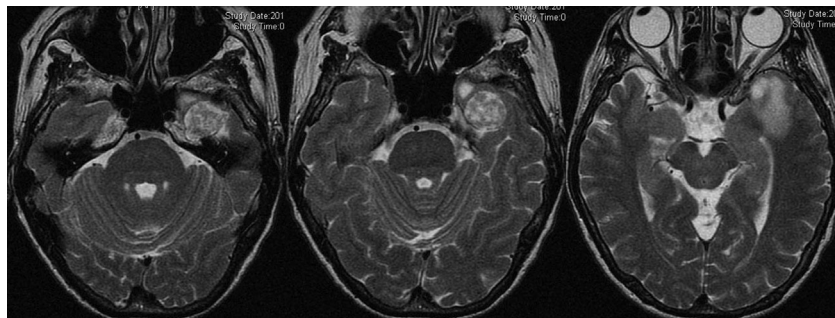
Axial T2-weighted magnetic resonance imaging shows a tumor located at the middle fossa with associated hyperintensity consistent with temporal lobe edema.
